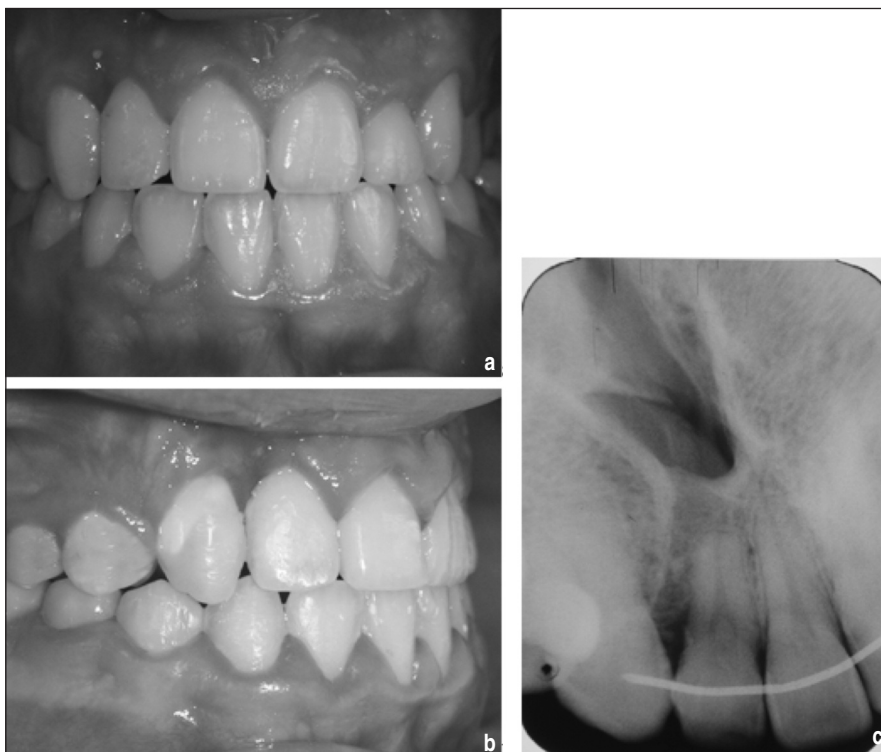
The four years follow-up records. a and b. Intraoral photos showing the defect region; c. Periapical radiographs showing improved bone material on the cleft side.
